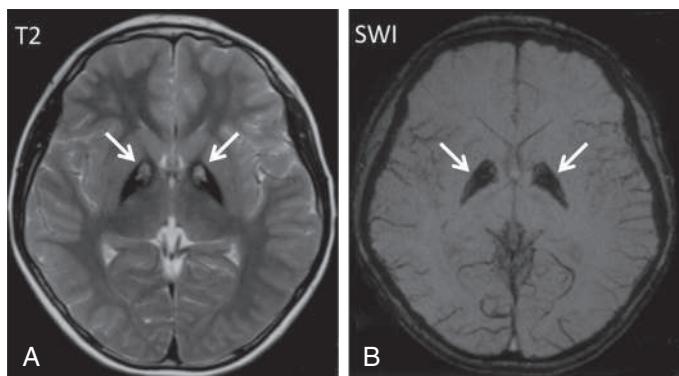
Pantothenate kinase–associated neurodegeneration (PKAN). A, Axial T2-weighted image showing symmetric hypointensity in the bilateral globi pallidi with central hyperintensity (eye-of-the-tiger sign, arrows). B, Axial susceptibility-weighted image (SWI) image showing hypointensity in the globi pallidi representing increased iron accumulation (arrows). (From Bosemani T, Meoded A, Poretti A. Susceptibility-weighted imaging in pantothenate kinase-associated neurodegeneration. *J Pediatr.* 2014;164:212.)
